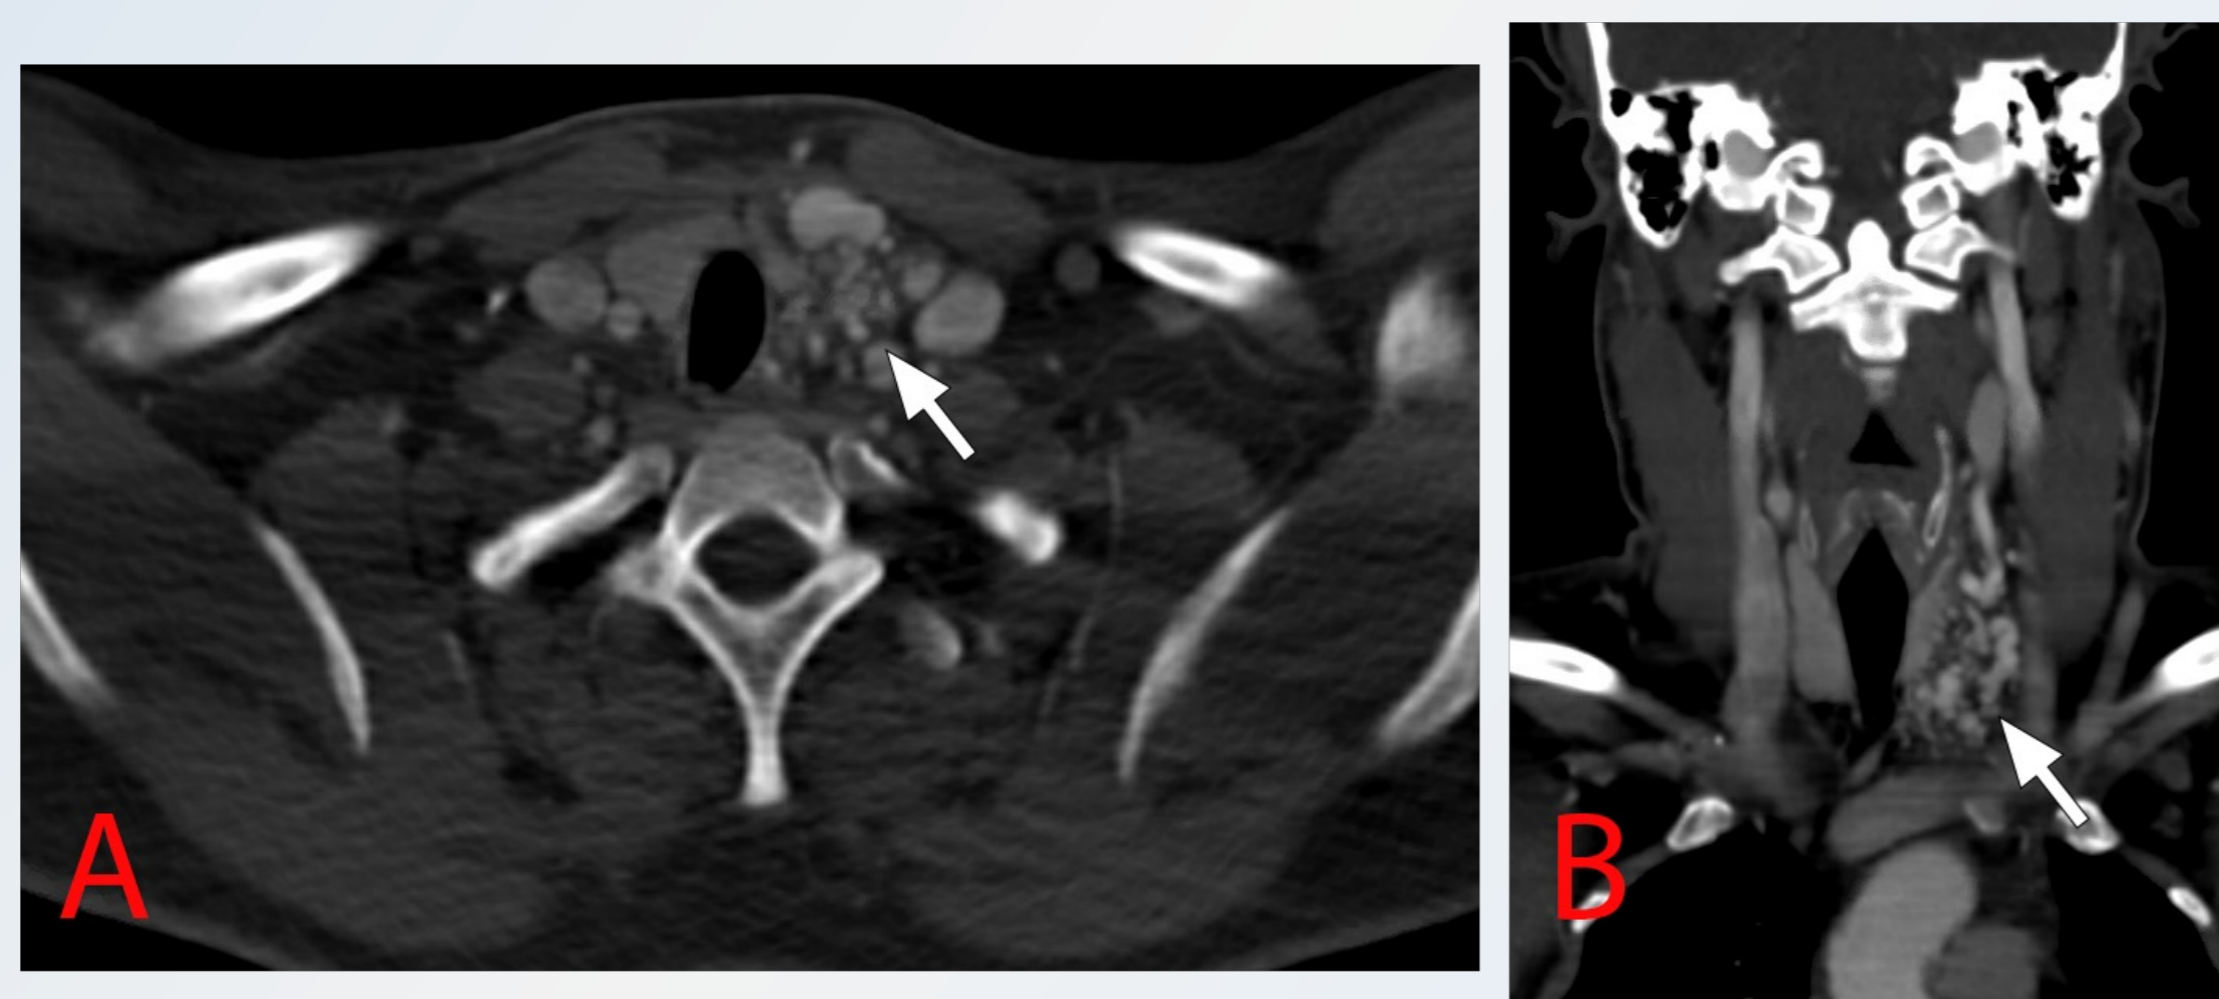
(A) Axial and (B) Coronal enhanced CT show multiple engorged arteries at the left lower neck (arrows) involving the thyroid/parathyroid region giving appearance of (bag of worms).
